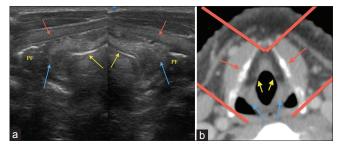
(a) Split/dual axial sections overlying thyroid cartilage using a linear transducer, demonstrating sonoanatomy of step 7 structures of either side (hypopharynx). (b) Corresponding computed tomographic section (red lines – representing the limit of ultrasound scan extent on either side) PF: Pyriform fossae; Red arrows, Thyroid cartilage; Blue arrows, Aryepiglottic folds; Yellow arrows, air-mucosal interface of larynx
